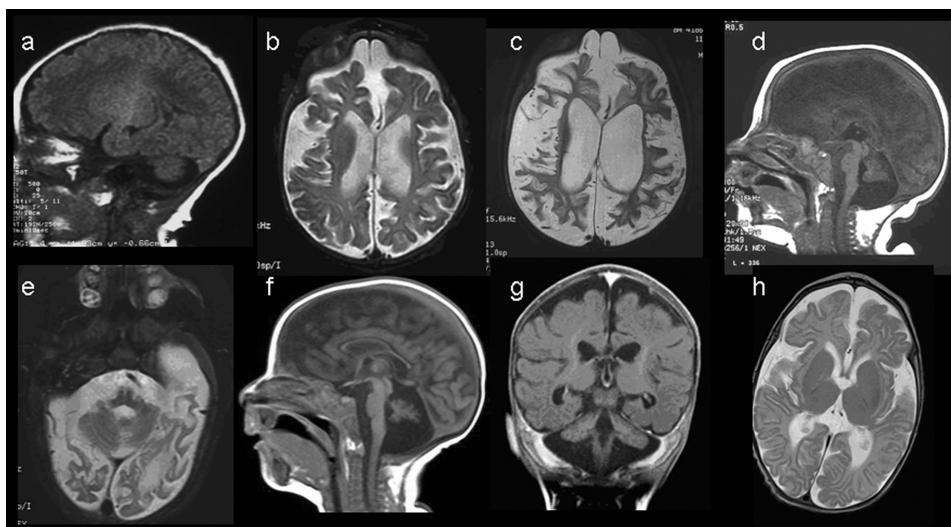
Brain MRI of patient II-2 (*a-e*) and patient II-5 (*f-h*). *a*, Sagittal T1-weighted image of patient II-2 obtained at age 3 d, showing hypoplasia of the cerebellum and the vermis, with progression at 5 mo (*d*). Brain volume was relatively preserved at age 3 d (*a*) but decreased at age 5 mo (*b*) and at age 9 mo (*c*), mainly because of white-matter depletion (panels *b* and *c* are axial T2-weighted images). *e*, Axial T2-weighted image of patient II-2 obtained at age 9 mo, showing severe pontine atrophy. Midsagittal (*f*) and coronal (*g*) T1-weighted images of patient II-5 obtained at age 3 mo show hypoplasia of the cerebellum and the vermis. *h*, Axial T2-weighted images disclosing some parenchymal loss, mostly of the white matter, with relative sparing of the basal ganglia and cortex.
